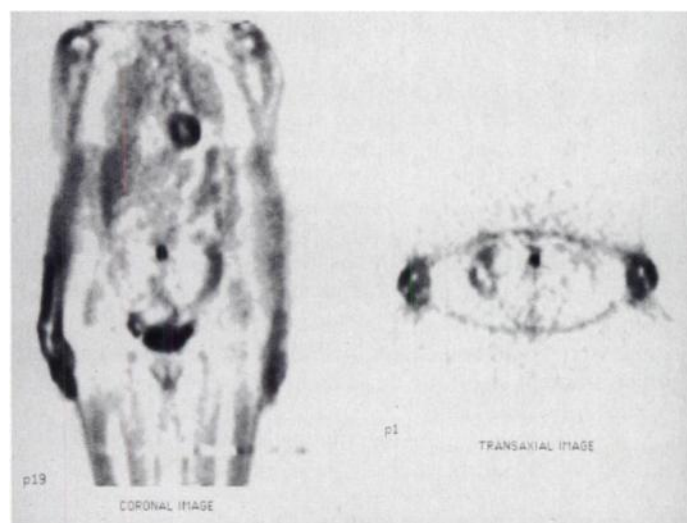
Coronal and transaxial whole-body FDG images in a patient with treated NHL. The patient was restaged and reported to have only a stable residual mass 1.5×2.5 cm in the left lower quadrant of the abdomen. Whole-body PET images show an intense focus of abnormal FDG activity in the periaortic region of the midabdomen consistent with the patient's recurrence of active disease.
